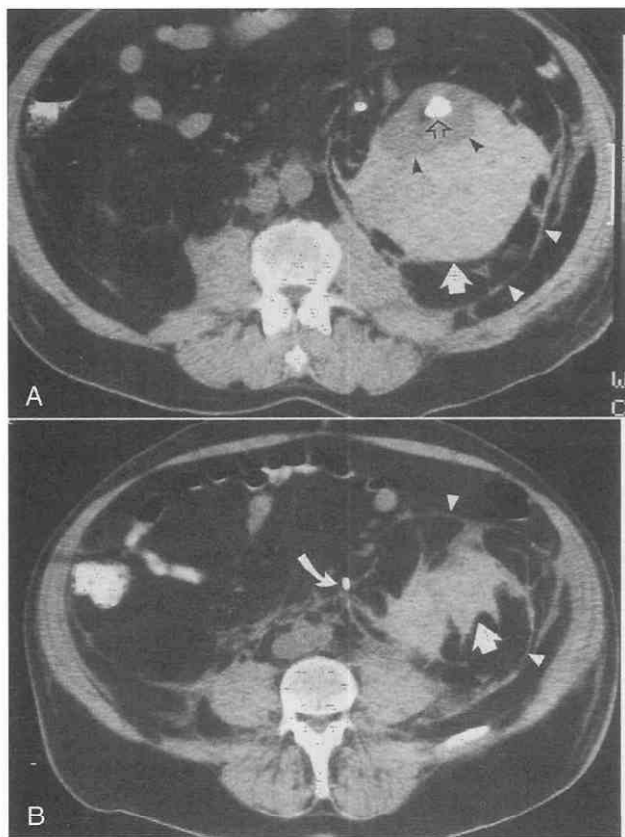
Left perinephric hematoma secondary to extracorporeal shock wave lithotripsy. *A*, An unenhanced CT scan reveals anterior displacement of left kidney (*black arrowheads*) by high-density hematoma (*arrow*). There is a calculus (*open arrow*) in the collecting system. The hematoma is limited posteriorly by the posterior renorenal bridging septum, which separates it from the thickened posterior renal fascia (*white arrowheads*). *B*, The hematoma (*white arrow*) extends into the infrarenal fascial cone (*arrowheads*). Infrarenal extension confirms the perinephric location of the hematoma and distinguishes it from a subcapsular hematoma. The left ureter (*curved arrow*) contains a stent and is displaced anteriorly.
